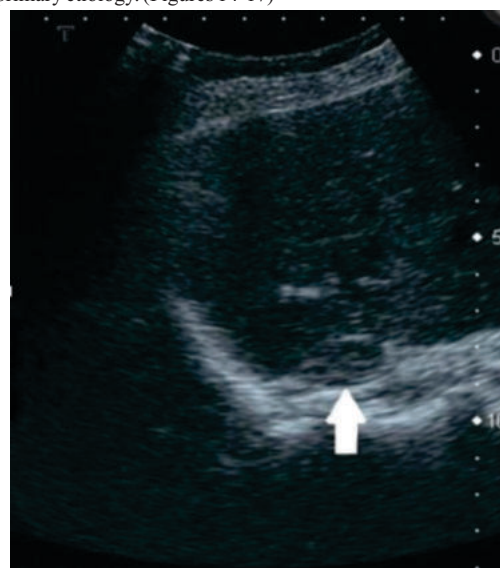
Ultrasound image of the adrenal gland demonstrate adrenal cortex adenoma. (White arrow)
